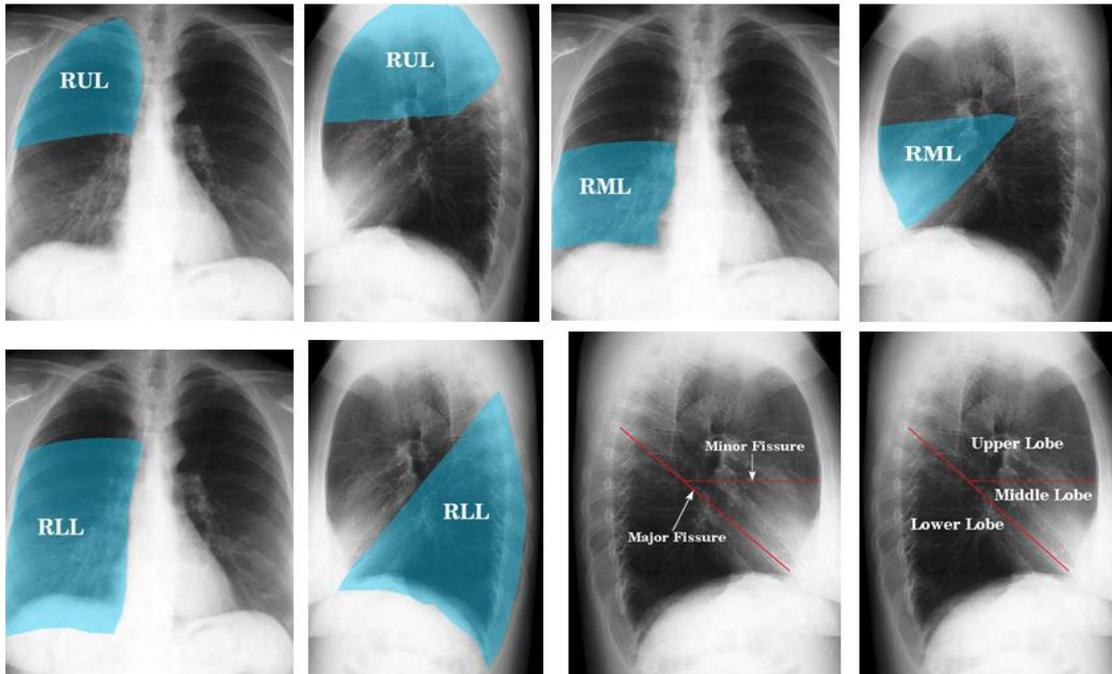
Chest radiographs of normal lung anatomy on posterior-anterior (PA) and lateral views. The lungs are divided into lobes by the fissures (Stephanie, 2011).
